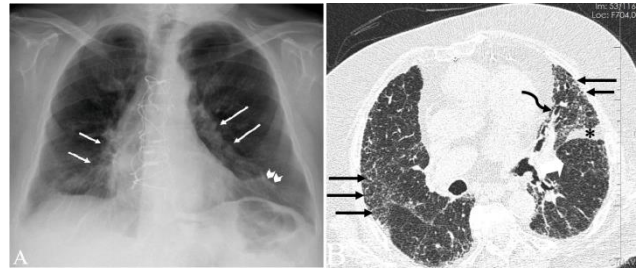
A 79-year-old male non-smoker with an obstructive PFT. PA chest X-ray shows bronchovascular thickening (*arrows, A*) and subsegmental atelectasis (*arrow heads, A*). Axial contrast-enhanced thorax CT image shows peripheral interlobular septal thickening (*black arrows, B*) in the bilateral lungs and subsegmental atelectasis in the left lung (*asterisk, B*). Note that the bronchial wall thickening and bronchiectasis (*curve arrow, B*) in the upper lobe of the left lung.
